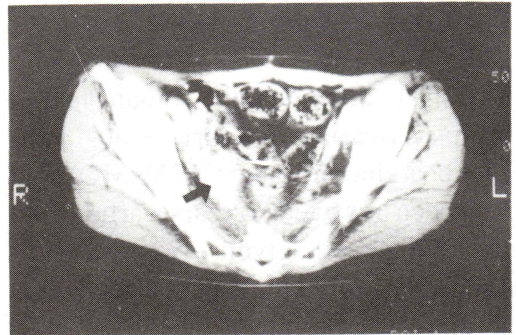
CT prior to the contrast enhancement features a tumour along the pelvic side wall, suggesting lymphadenopathy. The dynamic CT scan was not effective in contrast enhancement of these nodes.
